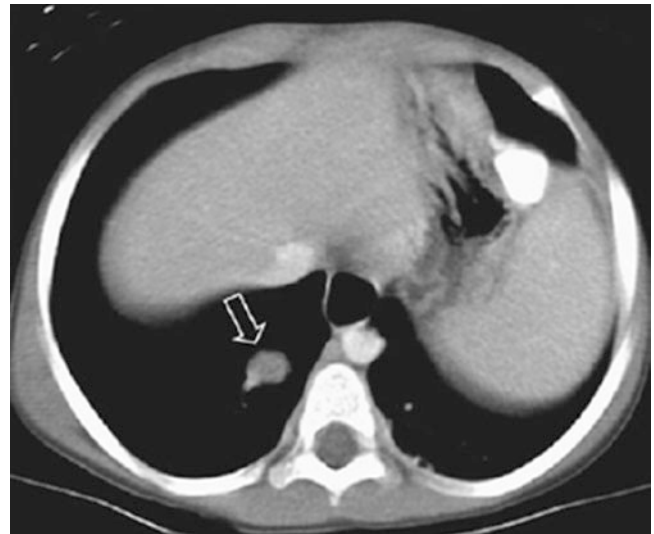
A 5-year-old boy with a history of Wilm's tumor. Right lower lobe lung mass (arrow) was detected on chest CT examination performed for the evaluation of thoracic metastatic disease. Enhanced axial CT image demonstrates a round pulmonary mass (arrow) with areas of low attenuation consistent with a fat component. Surgical pathology was consistent with a diagnosis of a pulmonary hamartoma
